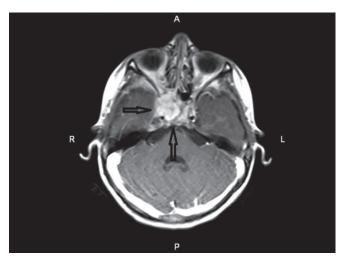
Axial T1 postcontrast MRI showing lesion mainly involving the right side of the basisphenoid
